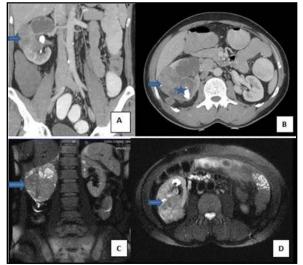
Xanthogranulomatous pyelonephritis: A and B (Contrast enhanced CT) -Exophytic enhancing lesion (arrow) involving posterior aspect mid part of right kidney. Multiple right renal stones (star) with focal hydro-calycosis of upper calyx. C and D (T2W coronal and axial)– A hypointense lesion involving posterior aspect mid part of kidney.
